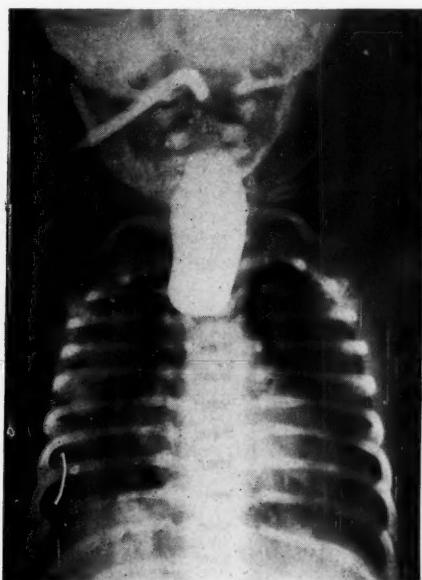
X-ray film of esophageal atresia with tracheo-esophageal fistula (Vogt Type 3b). Lipiodol has been instilled into upper esophageal segment which ends as a blind pouch at the level of the third thoracic vertebra. There is gaseous distention of the intestine, denoting a tracheo-esophageal fistula of the lower esophageal segment.
